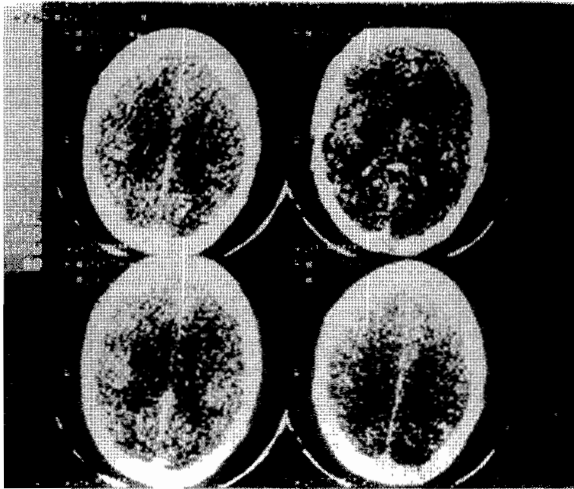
Contrast enhanced cranial CT for patient number 2 showing wide spread irregular contrast enhancement in addition to finding in 2a.
